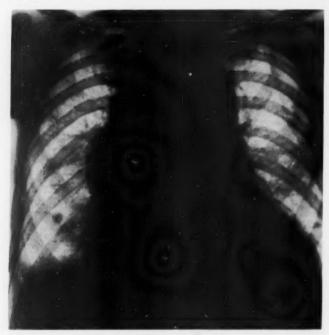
Chest x-ray, 1955.
